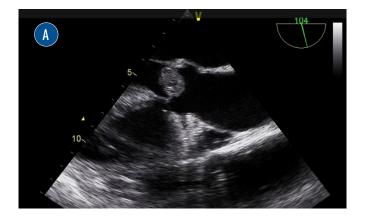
Aortic valve vegetation during transesophageal echocardiogram. Left Panel (A), Mid-Esophageal Transgastric View; Right Panel (B), Mid-Esophageal Aortic Valve Short Axis View.
